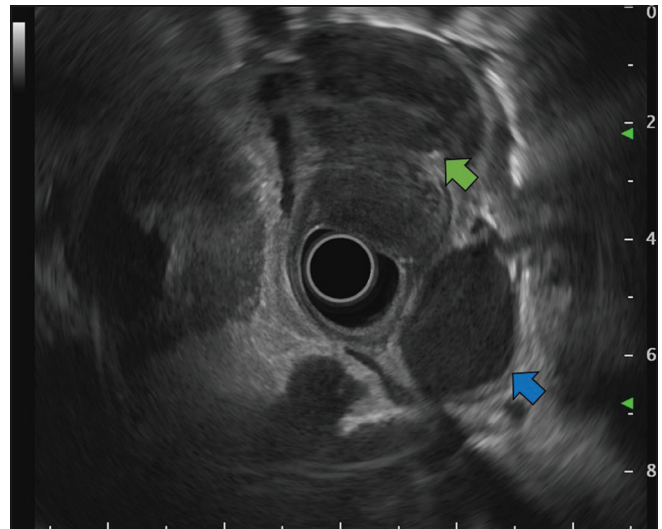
Endoscopic ultrasound revealing two lobulated tumors (green and blue arrows) derived from the muscularis propria showing heterogeneous hypoechoic features and poor blood flow signals
